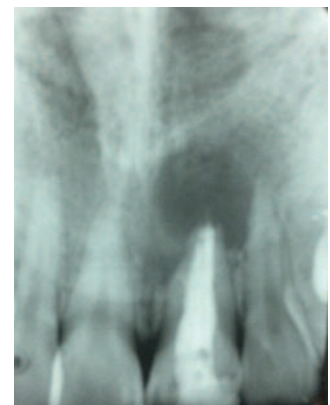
Initial radiography.
